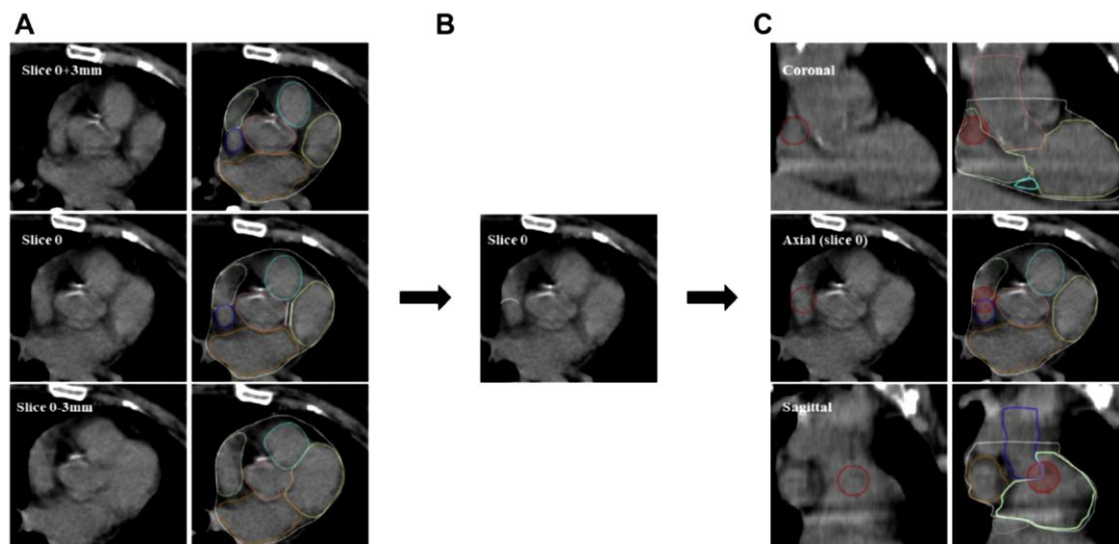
Step-by-step delineation of the sinoatrial node (SAN). Slice thickness is 3 mm. The heart (white), aorta (pink), superior vena cava (SVC; blue), inferior vena cava (gray), right atria (light green), left atria (orange), right ventricle (cyan), and left ventricle (yellow) have been delineated. (A) Identify the lowest computed tomography (CT) slice where the aorta appears separated from the left ventricle (identified as Slice 0 on the provided example). Separation between the aorta and left ventricle is materialized by white brackets on Slice 0. (B) Identify on this CT slice (Slice 0) the SVC and right auricle (identification of SVC contours is eased by scrolling up and down the CT slices). The junction between the SVC and right auricle is materialized by a white dotted line. (C) The SAN is delineated by the 2-cm diameter sphere centered on the junction between the SVC and right auricle on this slice (Slice 0), so that the border of this sphere is in contact with the right border of the heart without exceeding the cardiac contours. The SAN spherical contours (red) are provided in the coronal, axial, and sagittal planes.
